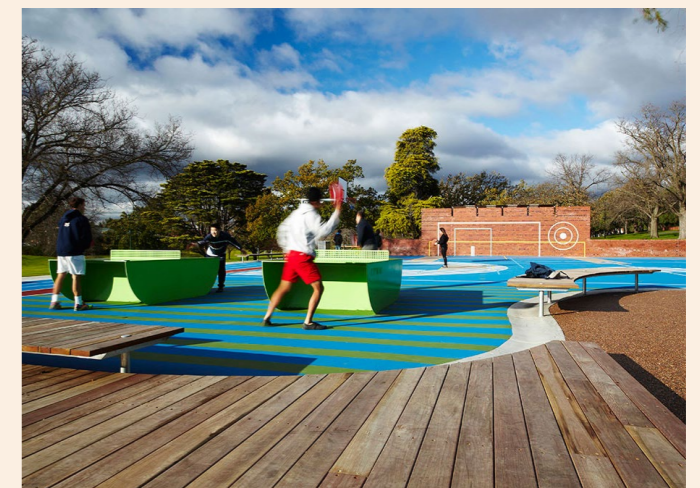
Box Hill Gardens by ASPECT Studios. Source: Andrew Lloyd
